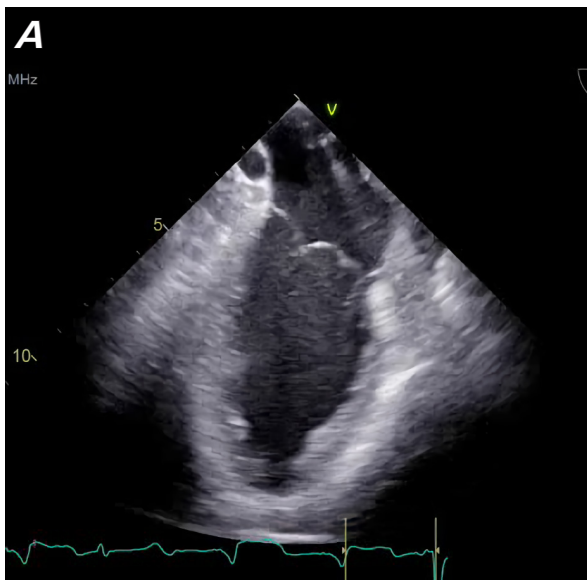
Vegetation resolution. Postsuction transesophageal echocardiography demonstrates resolution of vegetations in A) the left ventricle and left atrium and B) the superior vena cava.
